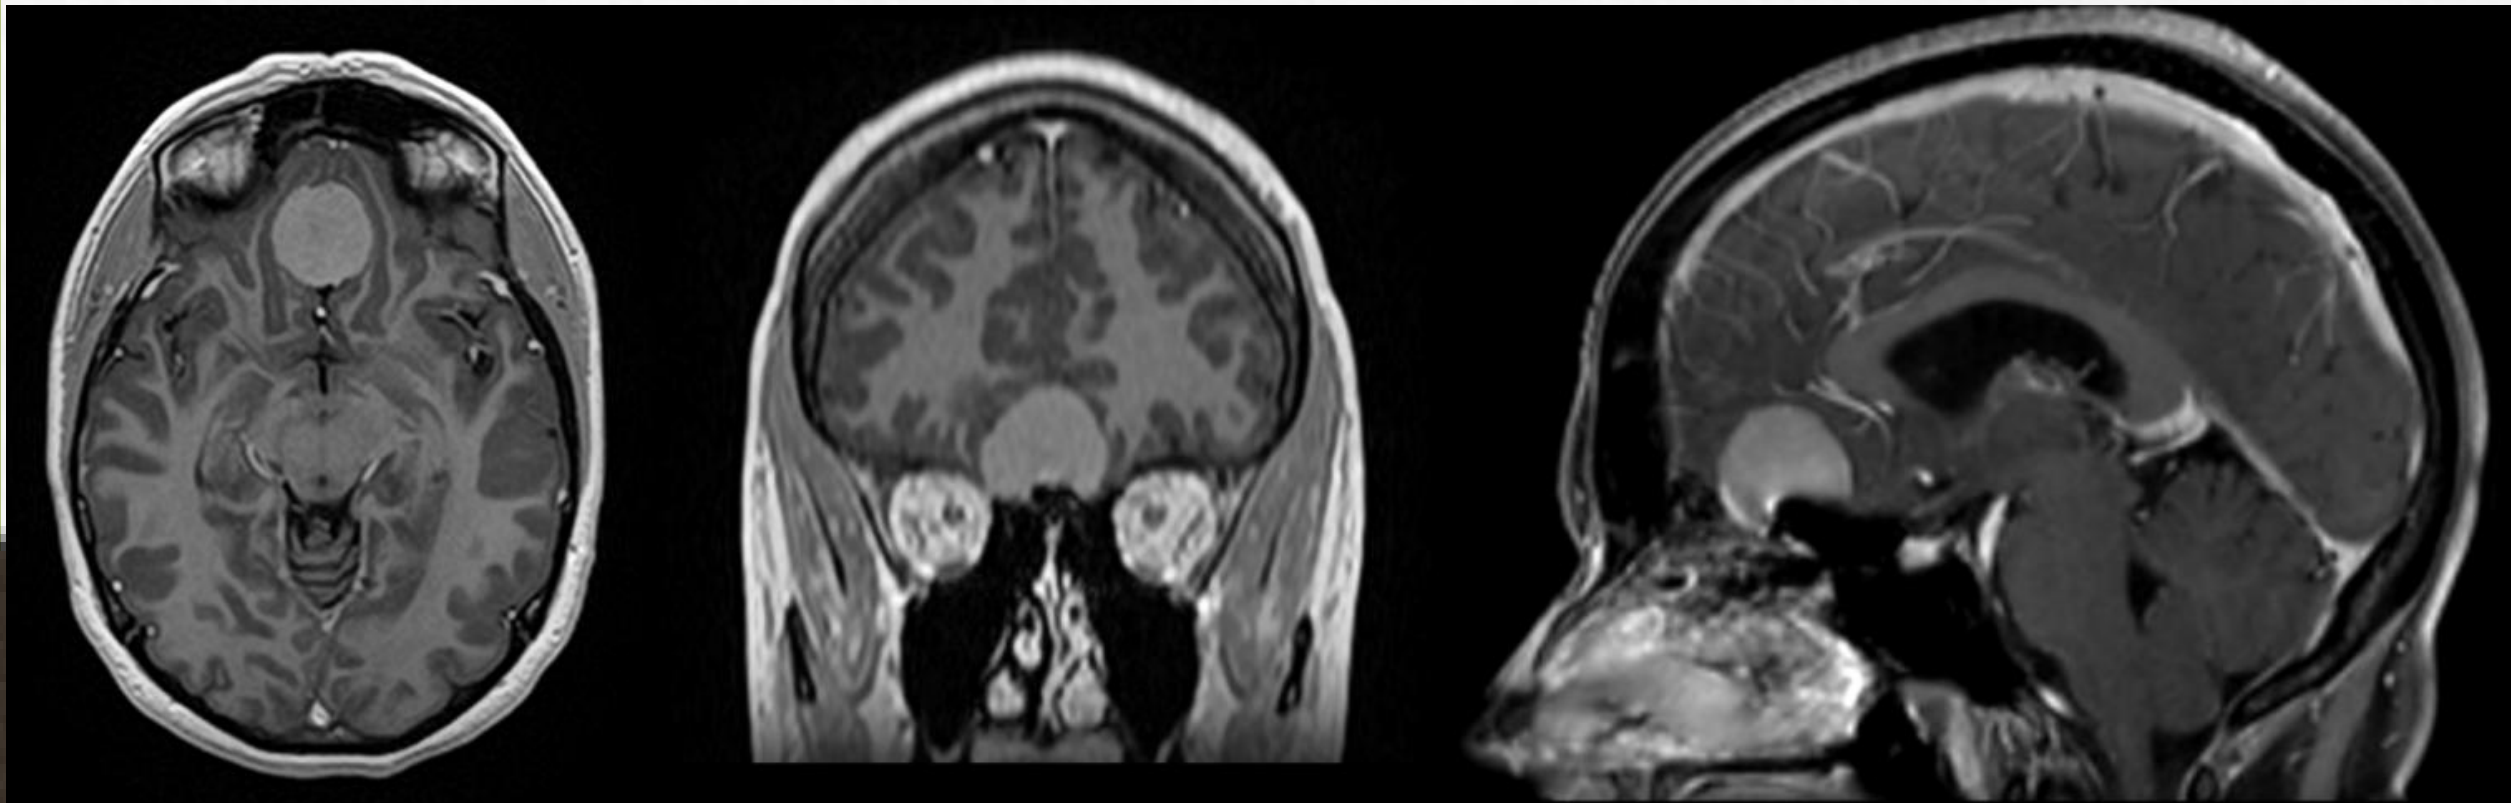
MRI head w/wo contrast reveals an anterior fossa olfactory groove meningioma measuring 2.6x2.7x2.1cm eccentric to the right with associated perilesional edema.
